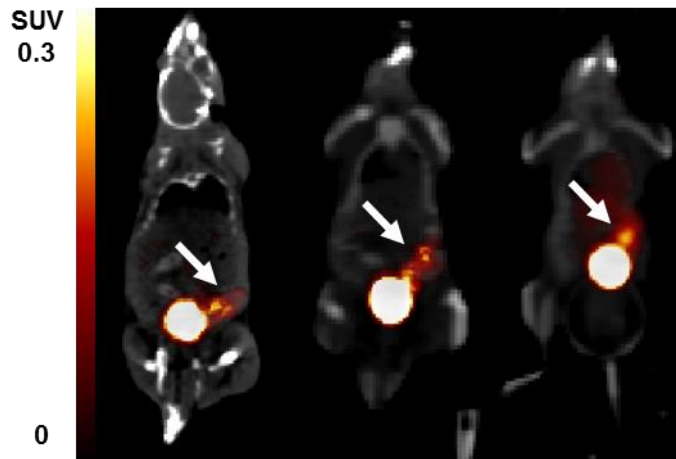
$[^{18}\text{F}]\text{FLT}$ uptake was visualised in the spleen of all healthy controls. Coronal-view PET/CT images of static splenic uptake of $[^{18}\text{F}]\text{FLT}$ 80–90 min post-radiotracer injection. Arrows indicate the spleen. Colour scale bar indicates SUV thresholding to aid visualisation.
